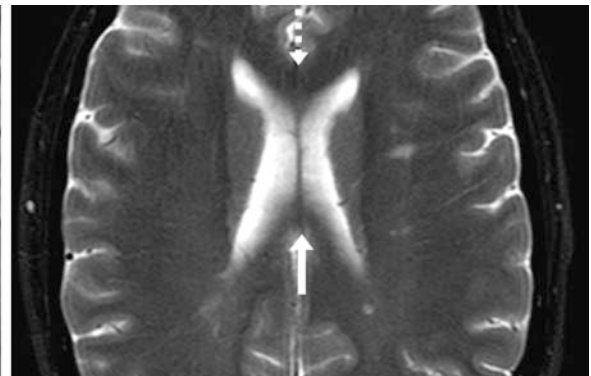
A 36 year old who underwent an MRI obtained for headaches (MRI was negative). There was a normal, slightly thinned callosal isthmus on a midline sagittal FLAIR image (*arrows, left*). An axial
